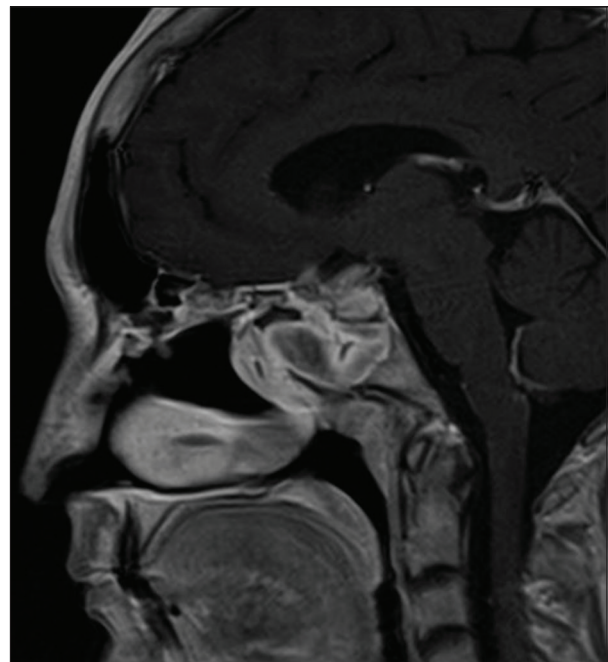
Post-trans-sphenoidal resection of the sellar/suprasellar tumour. Follow-up sagittal T1 post-gadolinium magnetic resonance image in midline shows residual changes in the sphenoid sinus with residual mucosal thickening, surgical defect in the sellar floor and residual enhancing tissue in the sellar/suprasellar cistern
